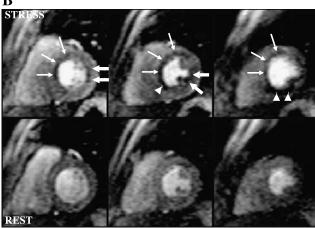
A thallium-201 perfusion study in a patient with 70% proximal LAD stenosis, 50% proximal LCX stenosis, and 80% proximal RCA stenosis (A). The thallium scan demonstrated inducible perfusion abnormalities in the septum, inferior wall, anteroapical wall, and apex (thin arrows show LAD territory, arrow heads show RCA territory). The lateral wall had normal stress perfusion. In the same patient, inducible perfusion abnormalities demonstrated by perfusion CMR with an EPI sequence in the antero-septal, inferior, infero-septal, lateral walls (thin arrows LAD territory, fat arrows LCX territory, arrow heads RCA territory) (B, C). The lateral wall perfusion abnormality detected with CMR was not seen with SPECT. The apical perfusion defect seen on SPECT was not seen on CMR with the long-axis views. The short- and long-axis views were acquired every cardiac cycle (B and C, respectively).
